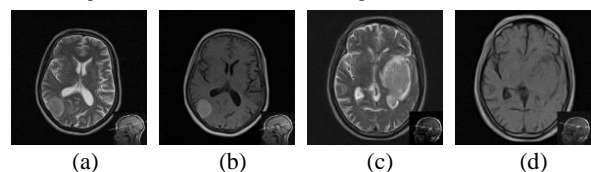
Original MRI data from pioneer diagnostic center showing tumor region intensity characteristics, (a) Low intensity (T2-w) (b) High intensity (T1-w), (c) High intensity (T2-w) and (d) Low intensity (T1-w) [20]
